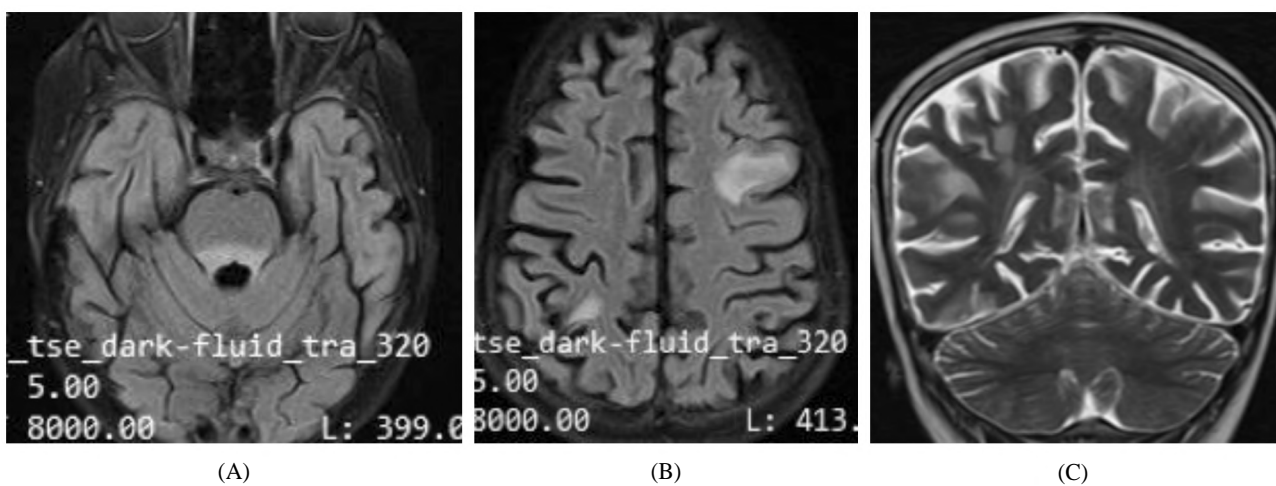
7 year old female child with COVID 19, laboratory proven, followed by convulsions and decreased conscious level, diagnosed with ADEM. CT images of chest (not shown) revealed no significant abnormality and CT score 0. (A,B) Axial FLAIR, (C) coronal T2WI, showing patchy area of high signal intensity in the posterior aspect of the pons (A) and multiple subcortical and periventricular white matter patchy areas of high signal intensity in T2 and FLAIR (in B and C).
